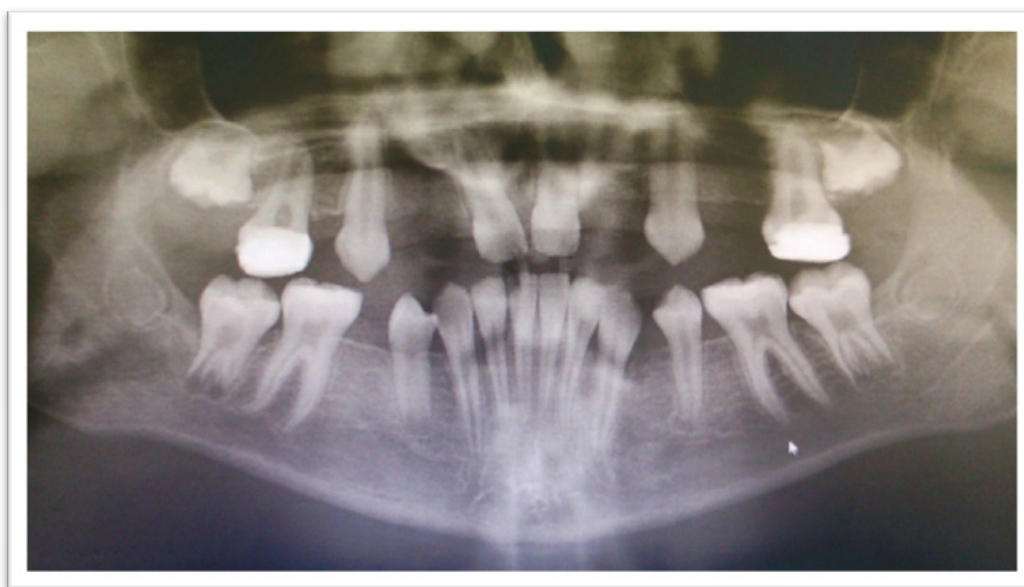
Orthopantomograph image of the patient
